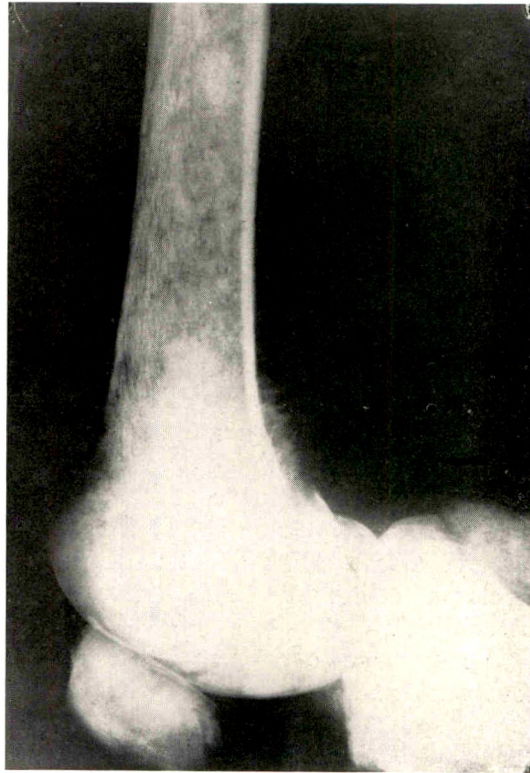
Lateral roentgenogram of right femur. The "whiskers" and areas of destruction are readily seen.
